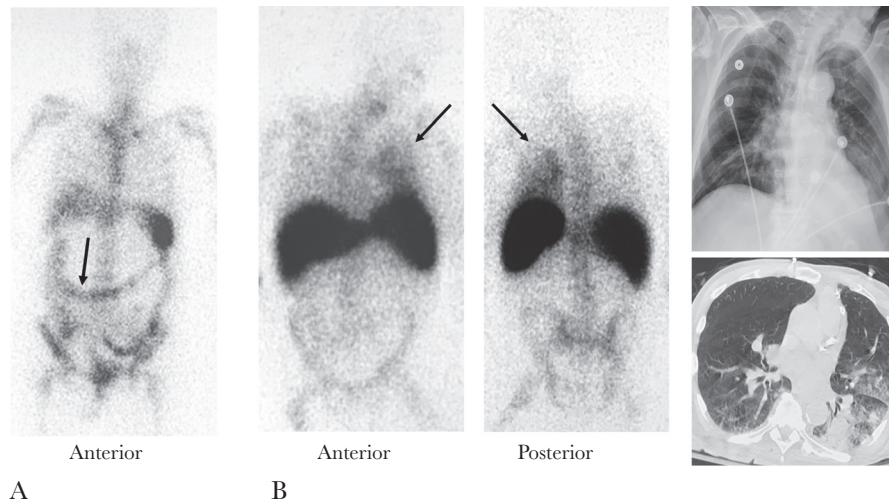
Examples of TP, but not helpful, scans. A, *C. diff* colitis. WBCS—note prominent uptake throughout nearly the entire the colon. *C. diff* labs had been requested 3 days before the scan but were delayed, and results came back a few hours after imaging. B (top), Pneumonia. Anterior and posterior images of WBCS showing large LLL pneumonia. CXR (upper right) showed this 24 hours earlier, and CT (bottom right) showed it 3 days later. Respiratory cultures came back (+) for MRSA 1 day after WBCS. The scan was requested primarily to exclude additional sources of infection. Abbreviations: ANT, anterior; *C. diff*, *Clostridioides difficile*; CT, computed tomography; CXR, chest x-ray; LLL, left lower lobe; MRSA, methicillin-resistant *Staphylococcus aureus*; POST, posterior; TP, true-positive; WBCS, white blood cell scintigraphy.
